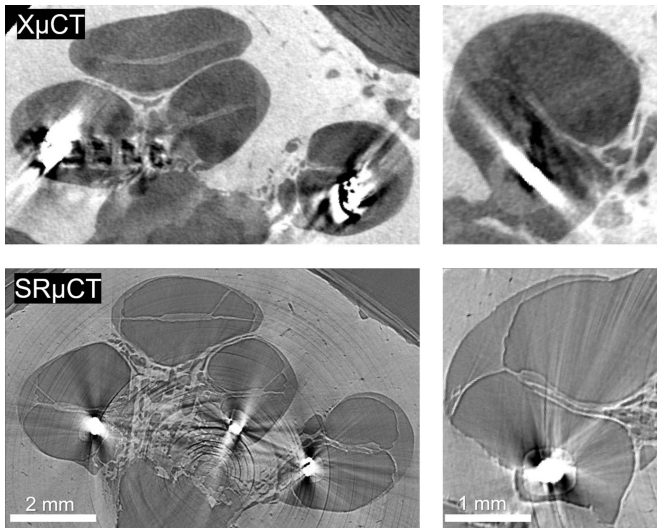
Conventional X-ray microfocus computed tomography ($X\mu\text{CT}$) versus synchrotron-based computed microtomography ($\text{SR}\mu\text{CT}$). Two different temporal bone samples were scanned, but the volumetric data were manually aligned to display similar cross-sectional views of the cochlea. Streak artefacts due to the highly absorbing platinum contacts were observed with both imaging techniques. However, in $\text{SR}\mu\text{CT}$ images, they were substantially less pronounced, allowing for the identification of fine anatomical structures in close proximity to the electrode contacts.
